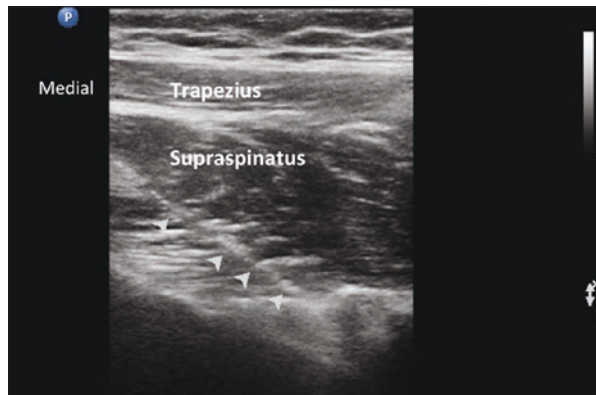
An ultrasound image of the posterior approach for the ultrasound-guided suprascapular nerve block demonstrating the suprascapular artery at base of the spine of the scapula. (Reprinted with permission from Pain Diagnostics and Interventional Care)
